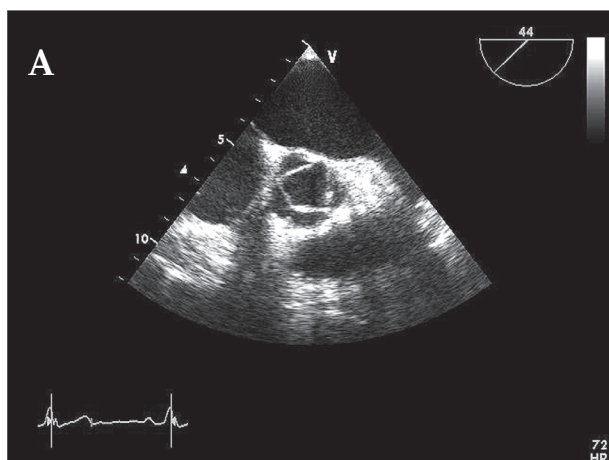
Transesophageal echocardiogram (TEE) short axis views in the vicinity of the aortic valve plane showing a quadricuspid aortic valve. (A) Left in systole and (B) right in diastole
